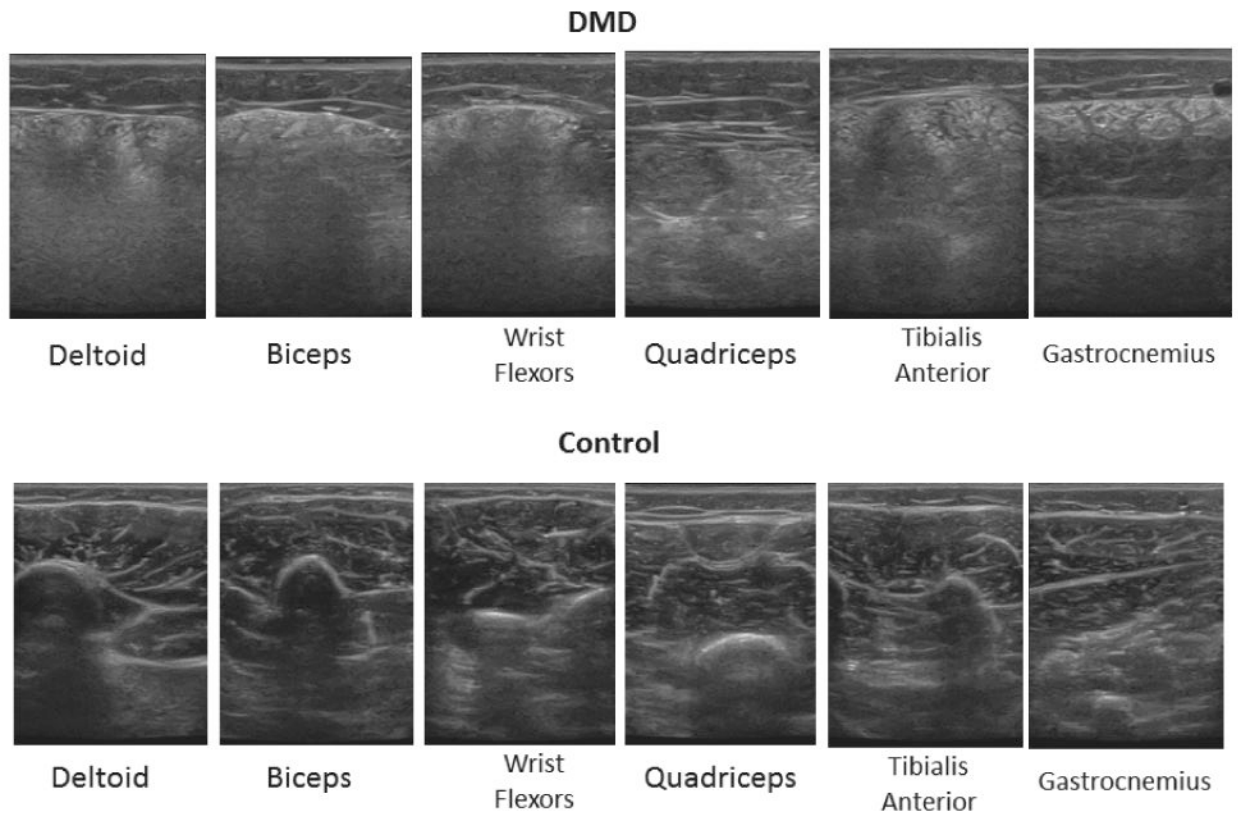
Ultrasound images of 6 muscles in a patient with DMD and a control participant. The 9-year-old patient with DMD (top row) has increased muscle echo intensity and obscuration of the intermuscular/intramuscular septa and bone compared to the 9-year-old control participant (bottom row).
